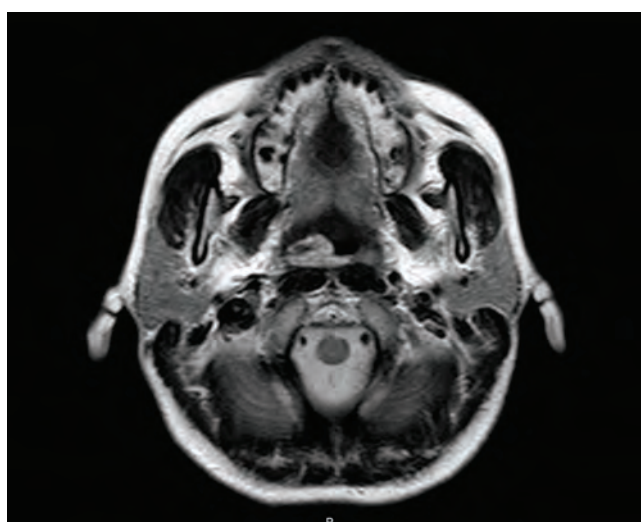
T2 axial slice MR image of the mass extending to the oropharynx
